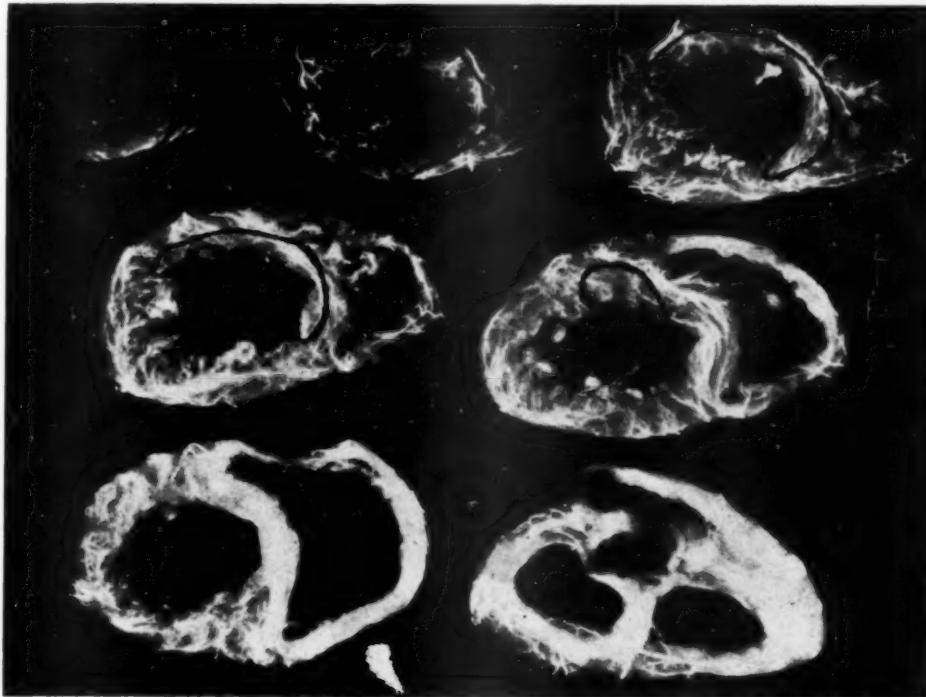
Roentgenogram of the injected heart in Case 65.
